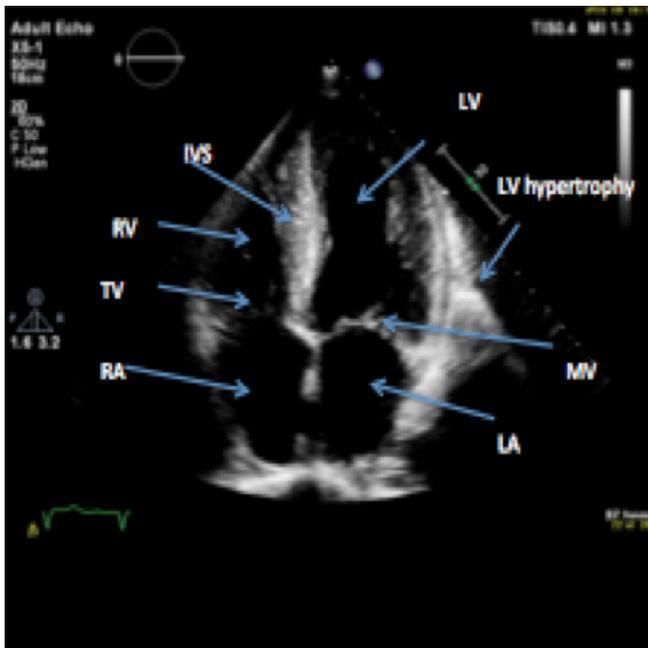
Echo images of the patient's heart. The image on the left is an apical 4-chamber view and a parasternal long axis view on the right. Note the thickened septum and concentric left ventricular hypertrophy. The myocardium has a characteristic granular sparkling appearance. LV= Left ventricle, IVS= interventricular septum, RV= Right ventricle, TV= Tricuspid valve, RA=Right atrium, LA=Left atrium, MV= Mitral valve.
